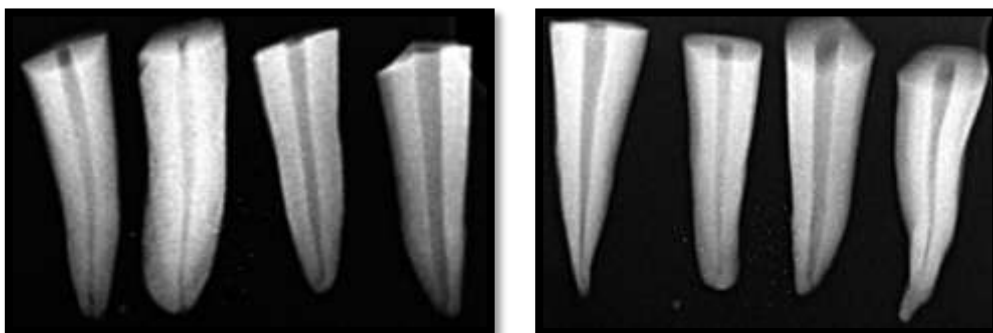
RADIOGRAPH AFTER BIOMECHANICAL PREPARATION
